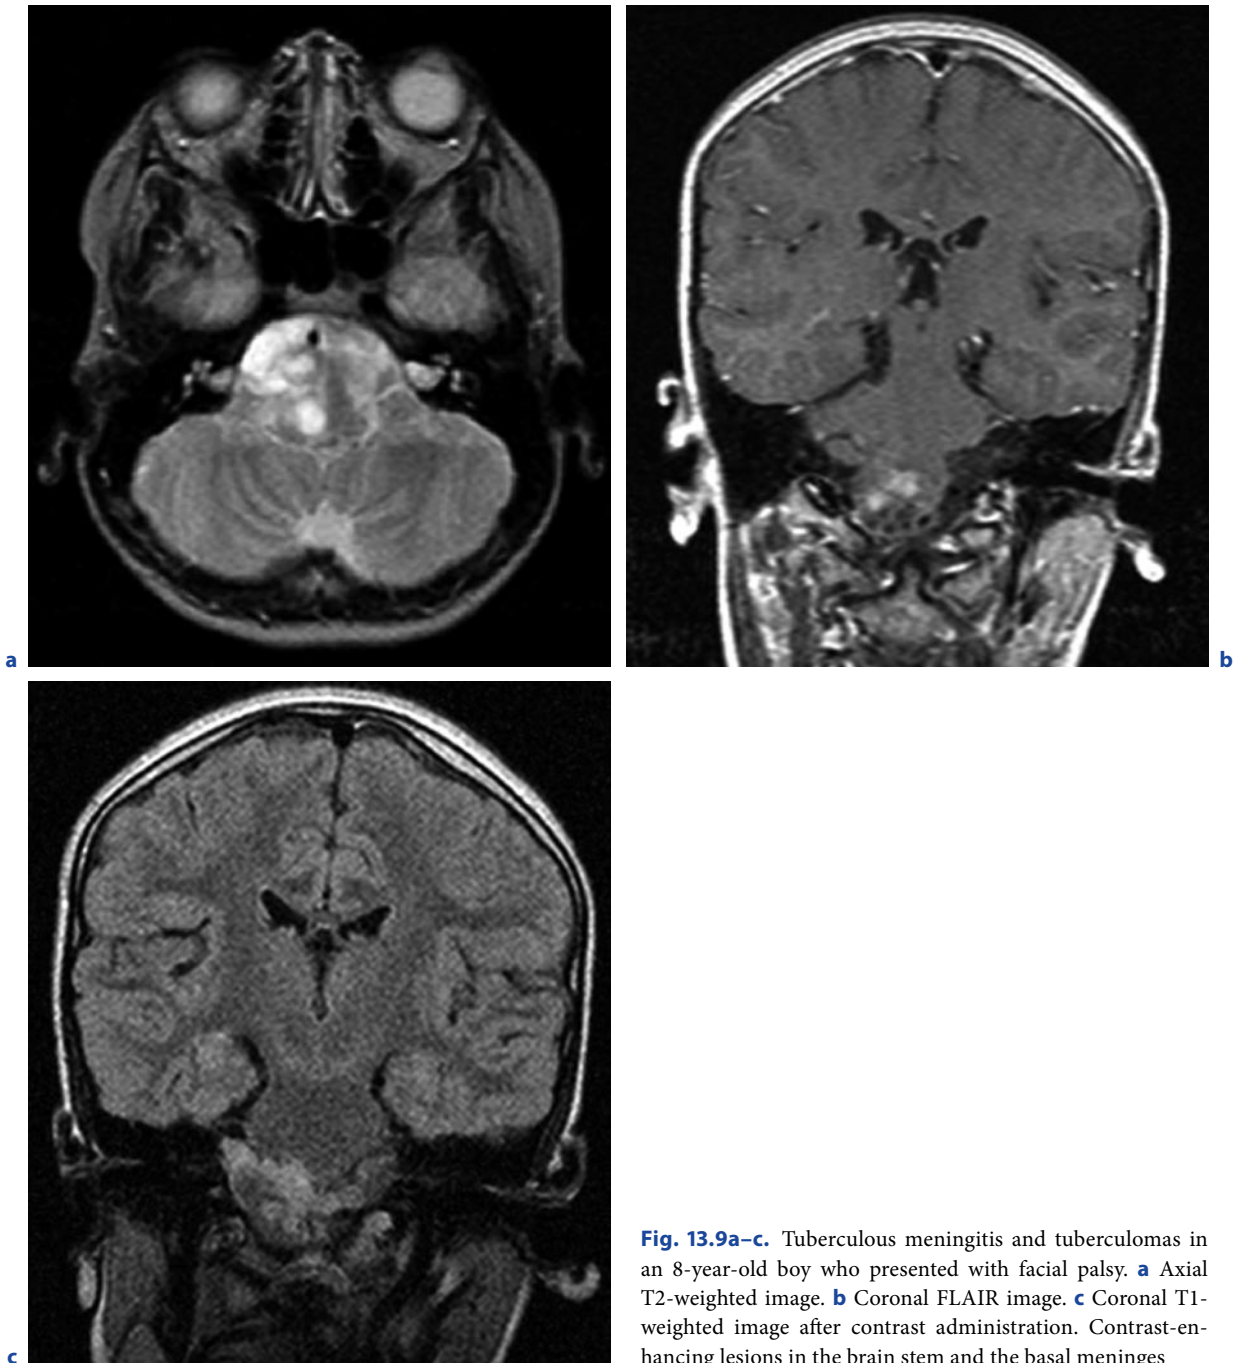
Tuberculous meningitis and tuberculomas in an 8-year-old boy who presented with facial palsy. a Axial T2-weighted image. b Coronal FLAIR image. c Coronal T1-weighted image after contrast administration. Contrast-enhancing lesions in the brain stem and the basal meninges
